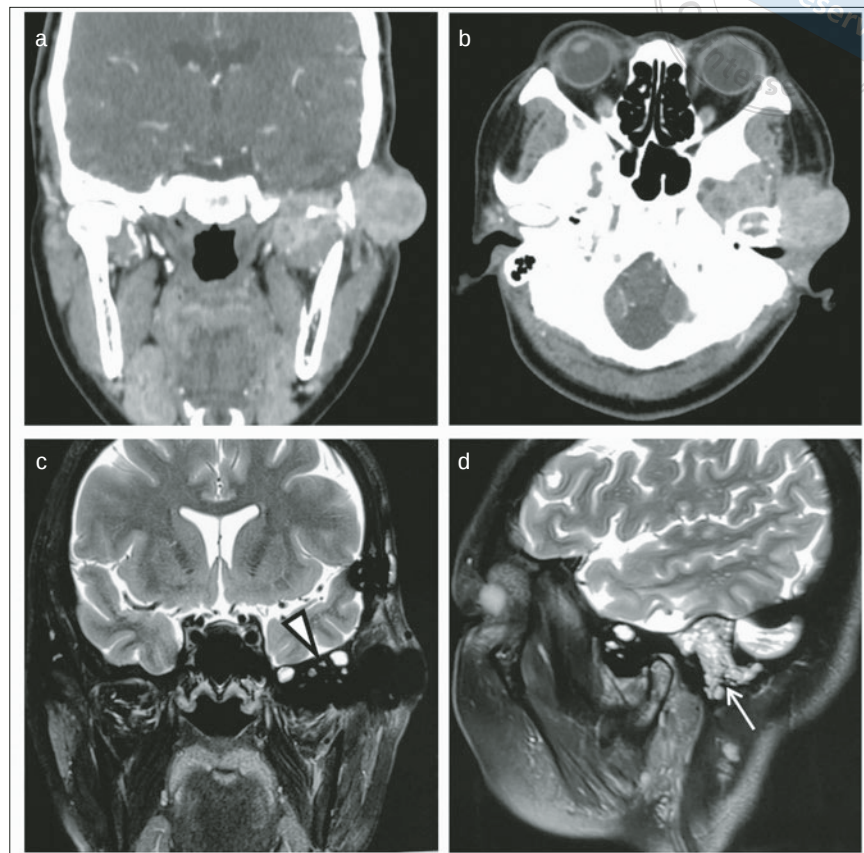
to d A case of D-TSGCT in the left TMJ with tumour invasion into the infratemporal fossa and middle cranial fossa. CT imaging showed the destruction of the skull base (a and b). MRI: the white triangle demonstrates intracranial extension of the mass with dural compression and associated flattening of adjacent cerebral gyri (c). The arrow showed punctate high signal in the mastoid air cells demonstrating mastoiditis (d).
